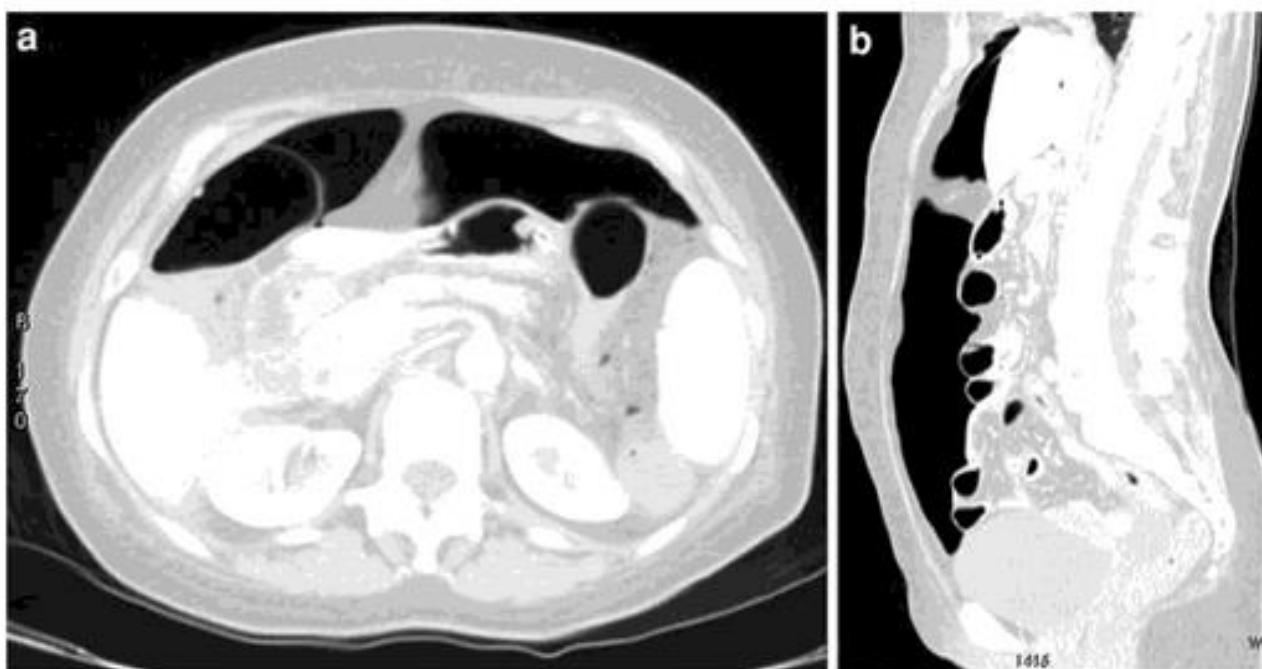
Intestinal perforation. Axial CT scan (a) and multiplanar sagittal reconstruction (b) show the presence of pneumoperitoneum, which is more evident with a lung window
